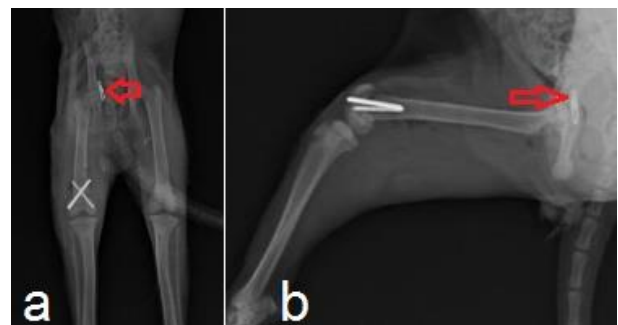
a) Postoperative VD radiograph, b) Postoperative ML radiograph
